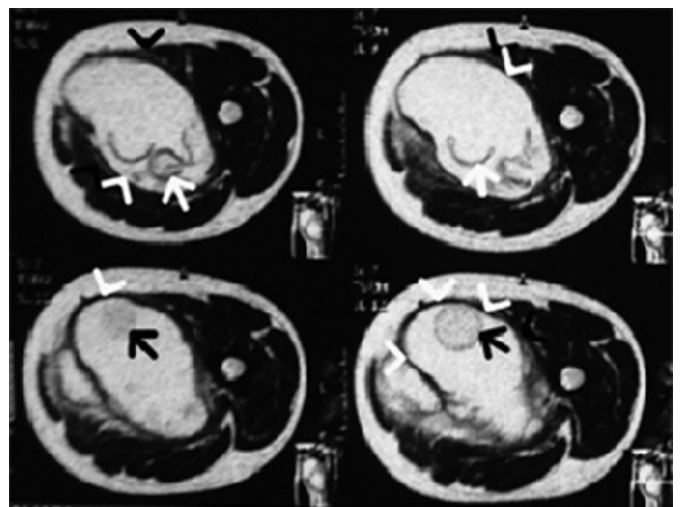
MRI of hydatid cyst within adductor muscle containing daughter cysts. T1-weighted spin-echo axial images demonstrate multiple daughter cysts showing lower signal intensity than the mother cyst (black arrows), an incomplete hypointense rim noted in the periphery of the mother cyst (white arrow heads).
